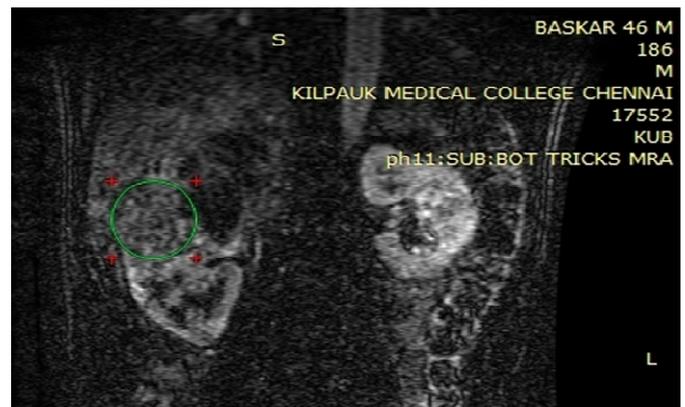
A DCE MRI Right Upper Pole mass
